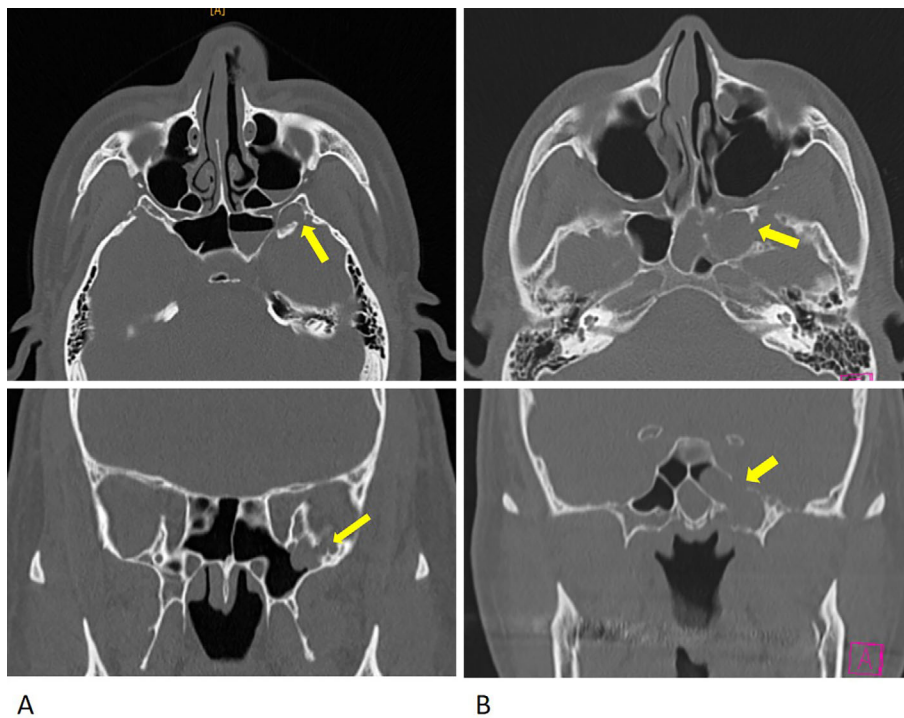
Head CT of the case 1 (A) and the case 2 (B). The arrows indicate a bony defect in the lateral wall of the left sphenoidal cavity.
